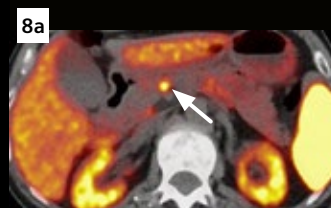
A Dotatate PET/CT image shows a small lesion spotted in the pancreatic body (Fig. 8a, arrow). The lesion is clearly seen in a cinematic VRT image created with Quantum HD images as well (Fig. 8b, arrow).
